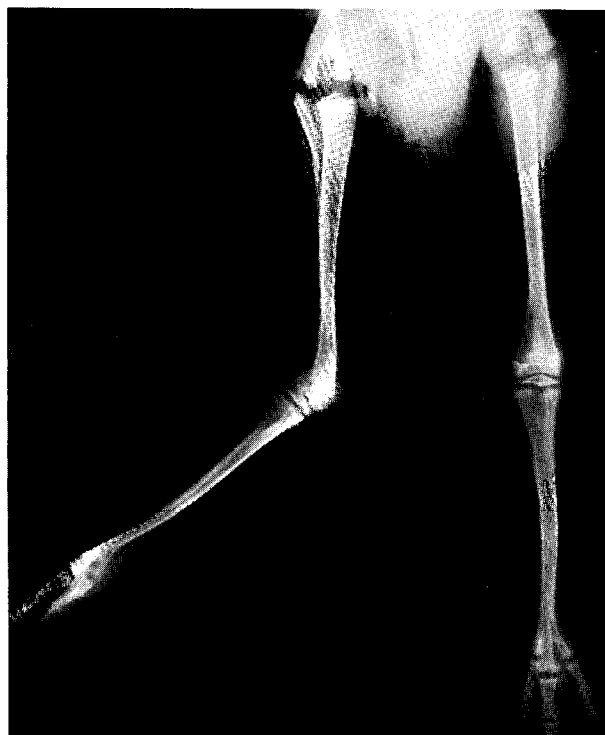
A ventrodorsal radiograph of the rhea showing the marked tibial rotation of the right leg.
